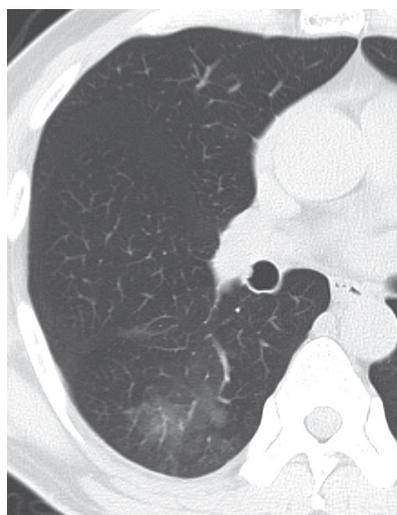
CT Shows Slightly Increased Attenuation in Right Segment 6, which was not Observed in CT for an Annual Check-up Performed 11 Months Later
